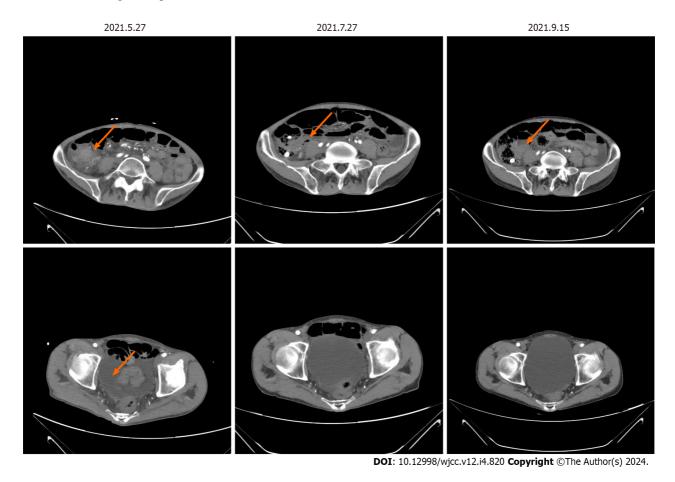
Contrast-enhanced computed tomography images of the whole abdomen after two and four cycles of treatment. The results of this evaluation indicated stable disease (arrows).
